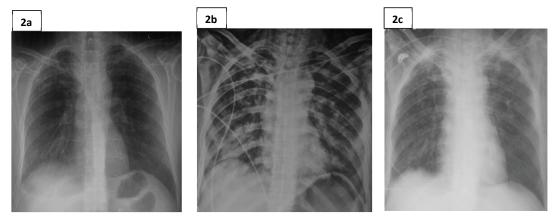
(2a) Pre operative chest radiograph posteroanterior view shows clear lung fields with widened superior mediastinum. (2b) chest radiograph anteroposterior view done post rigid bronchoscopy shows bilateral alveolar opacities consistent with pulmonary edema. Straight metallic stent and endotracheal tube are also seen. (2c) chest radiograph anteroposterior view showing resolution of alveolar opacities within 24 hours of positive pressure ventilation.
